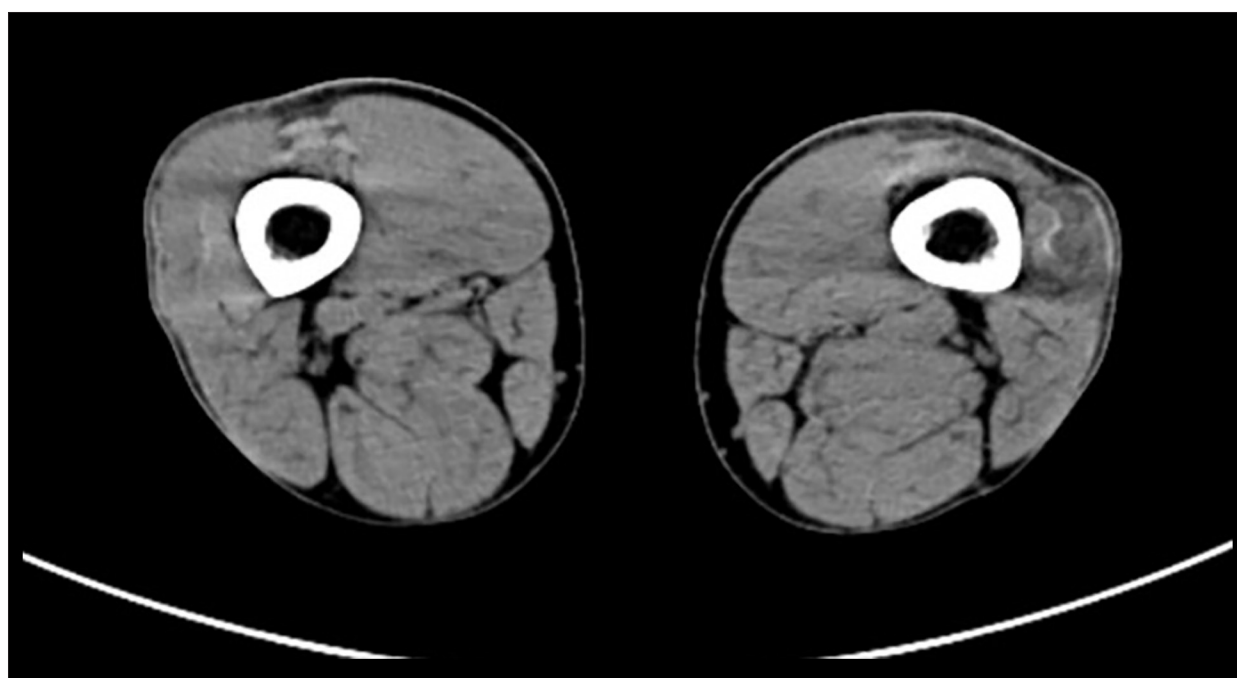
Computed tomography scan of the left thigh.
